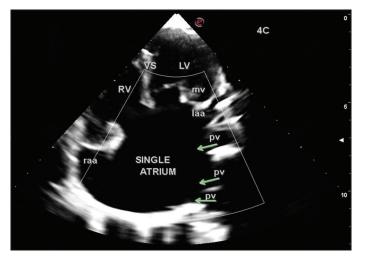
Apical 4 ch view – three pulmonary veins opening into the left lateral side of single atrium (sinistral part). Identical left and right atrial appendages are also visualized
